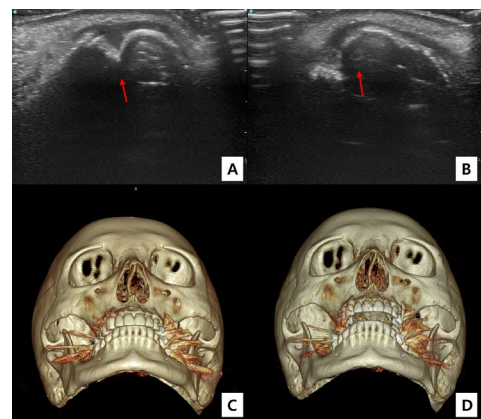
Representative case using the wireless V-scan. (A, B) Pre- and postoperative ultrasound images guiding the reduction. (C, D) Corresponding pre- and postoperative CT scans confirming accurate alignment.
